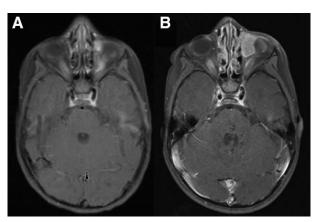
A, MRI of the orbit 6 months prior to presentation showing a small mass in the inferomedial left orbit. B, Compared with the MRI image at the time of the orbital mass biopsy.
